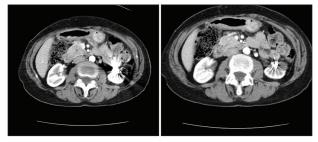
Follow-up CT scans at 1 year showing nearly complete aneurysm resolution and no evidence of AVM.
